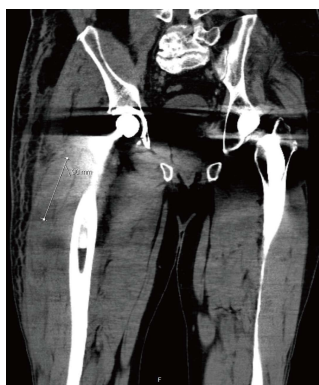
Coronal plane computed tomography scan showing a hematoma of the anterior compartment.
